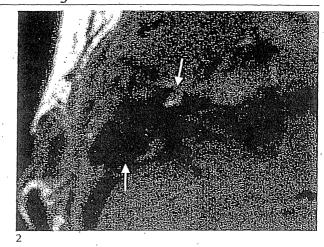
(Case 6) Right ear contrast-enhanced MRI: 1 = preoperative, 2 = six months after facial nerve decompression surgery [Patient MRI Findings]
